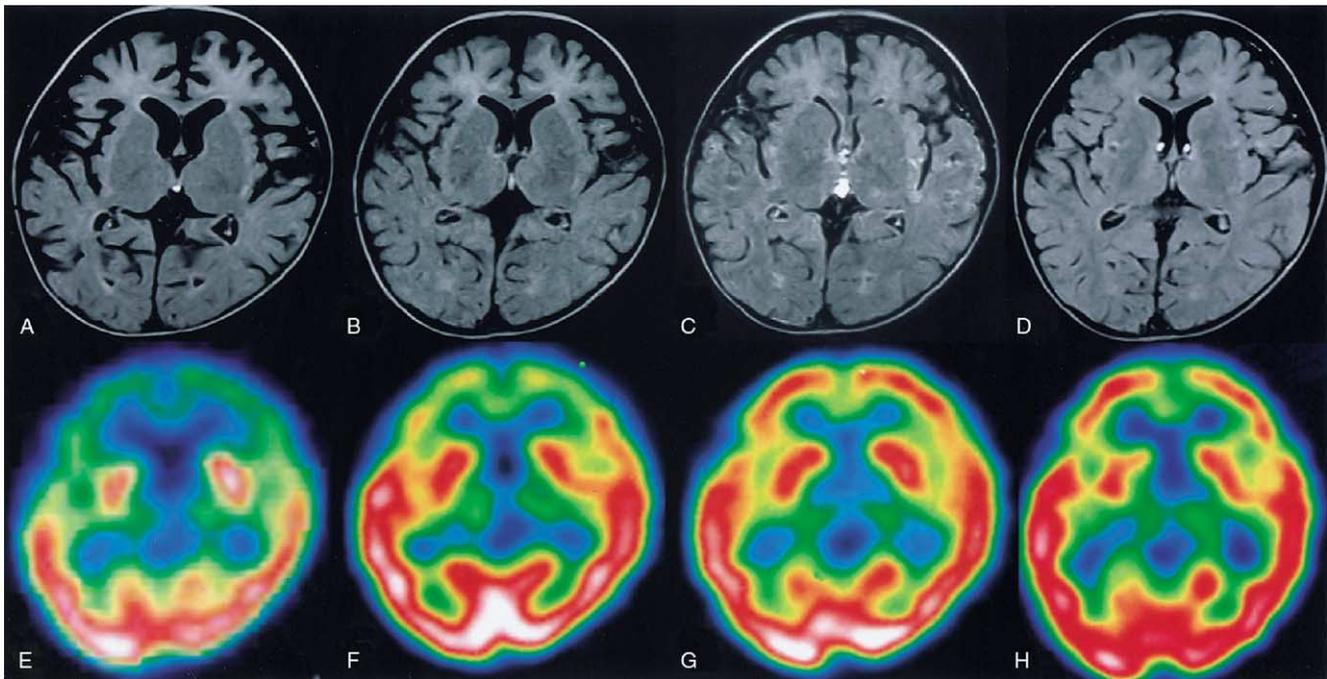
Serial magnetic resonance imaging (A, B, C, D: fluid-attenuated inversion recovery image, 6744 ms/110 ms/1588 ms) and single-photon emission computed tomography (E, F, G, H: ^{99m}Tc -ethyl cysteinyl dimer) studies in Patient 3, which were performed at the 21st day (A, E), the twelfth month (B, F), the 38th month (C, G), and the 52nd month (D, H) from the onset. Markedly decreased perfusion and atrophic changes were observed in the frontal lobes at the 21st day (A, E). The decreased perfusion was improved at the 12th month, and then normalized at the 38th month or subsequently. High signal intensities in the white matter of the frontal lobes were observed between the 21st day and the 38th month, and disappeared at the 52nd month.
